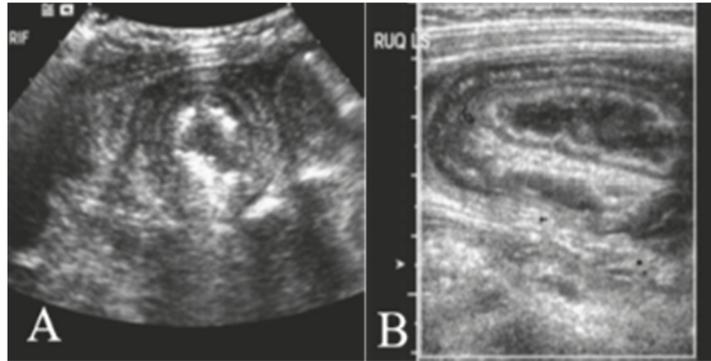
Ultrasound images. A cross-section (target); B longitudinal section (kidney-like)
